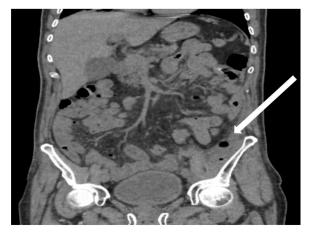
No postoperative residue was observed in the coronal section CT examination (white arrow) *CT: Computed tomography*
